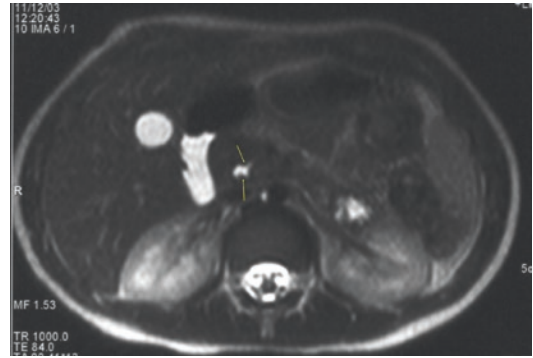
MR imaging axial T2-weighted sequence on a 7-year-old boy with CBPC: The pancreatic and bile ducts join into a CBPC (*small yellow arrow*) far from the ampulla, within the pancreatic head. *Small dashed arrow* reveals a lithiasis in hyposignal in a dependent position within the common bile duct
